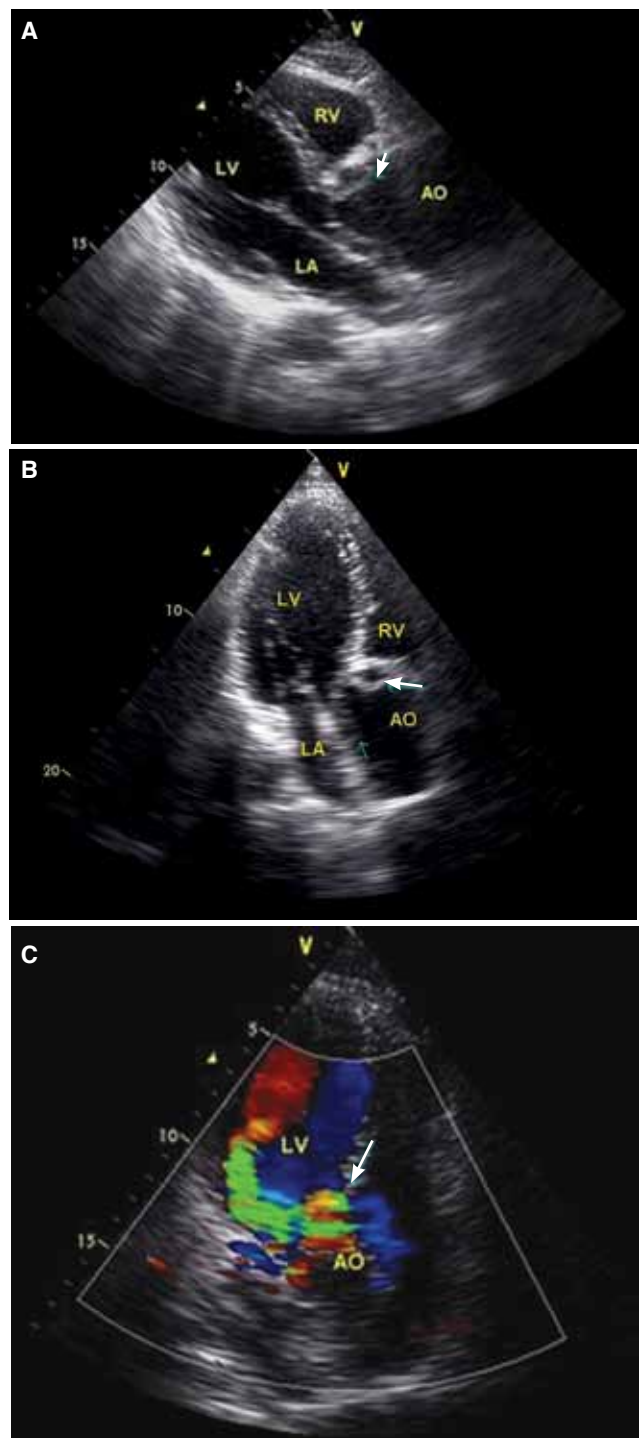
(A, B) Transthoracic echocardiograms showing an intimal flap prolapsing into the left ventricular outflow tract during diastole (arrow). (C) Color Doppler image in the apical five-chamber view shows severe aortic regurgitation (arrow). AO: Aorta; LA: Left atrium; LV: Left ventricle; RV: Right ventricle.
